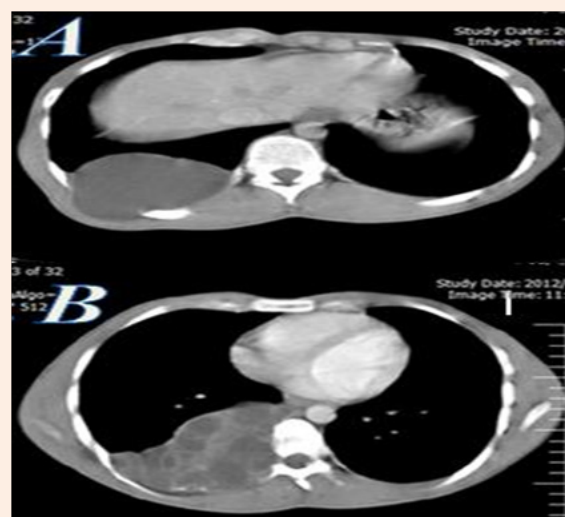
CT scans of thorax (A,B) with IV contrast showing rib distraction and cystic mass of seven rib.
